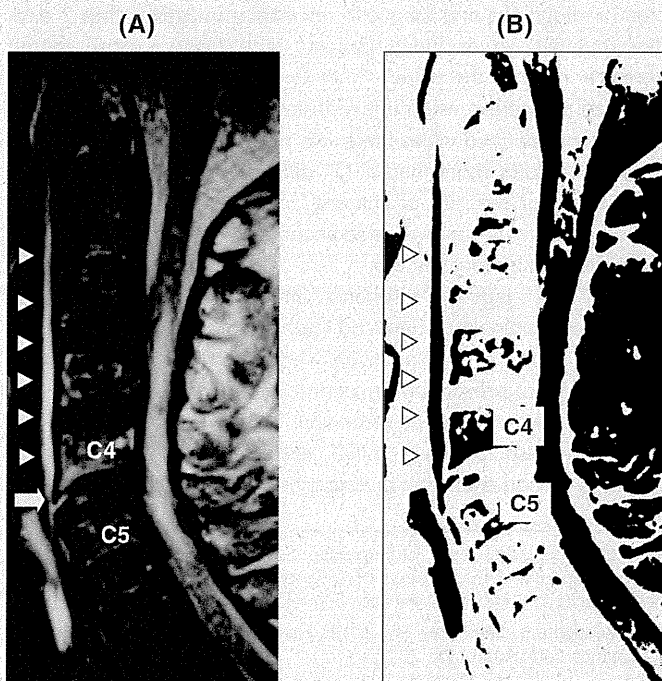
(A) A T2-weighted magnetic resonance image obtained a day after trauma. The anterior longitudinal ligament and disc disruptions are evident at the C4–C5 segment (arrow). There is prevertebral hyperintensity, presumably reflecting fluid collection or hemorrhage (arrowheads). (B) The area of prevertebral hyperintensity (arrowheads) was measured using the ImageJ software program.
